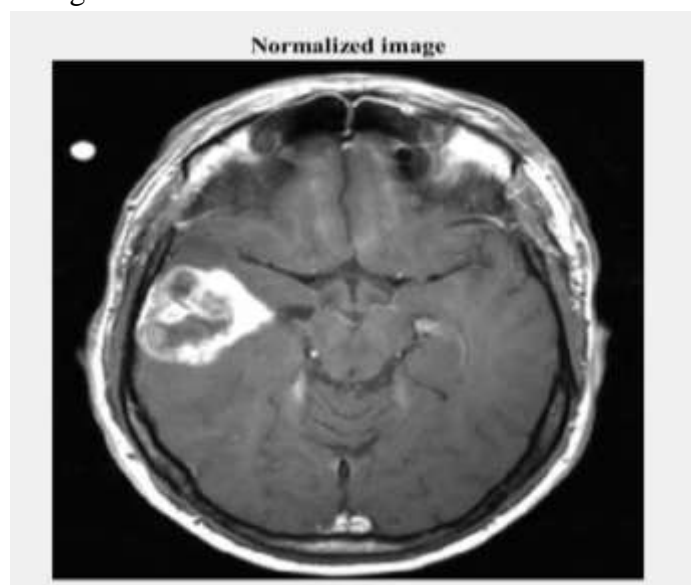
Normalized Input MRI image
